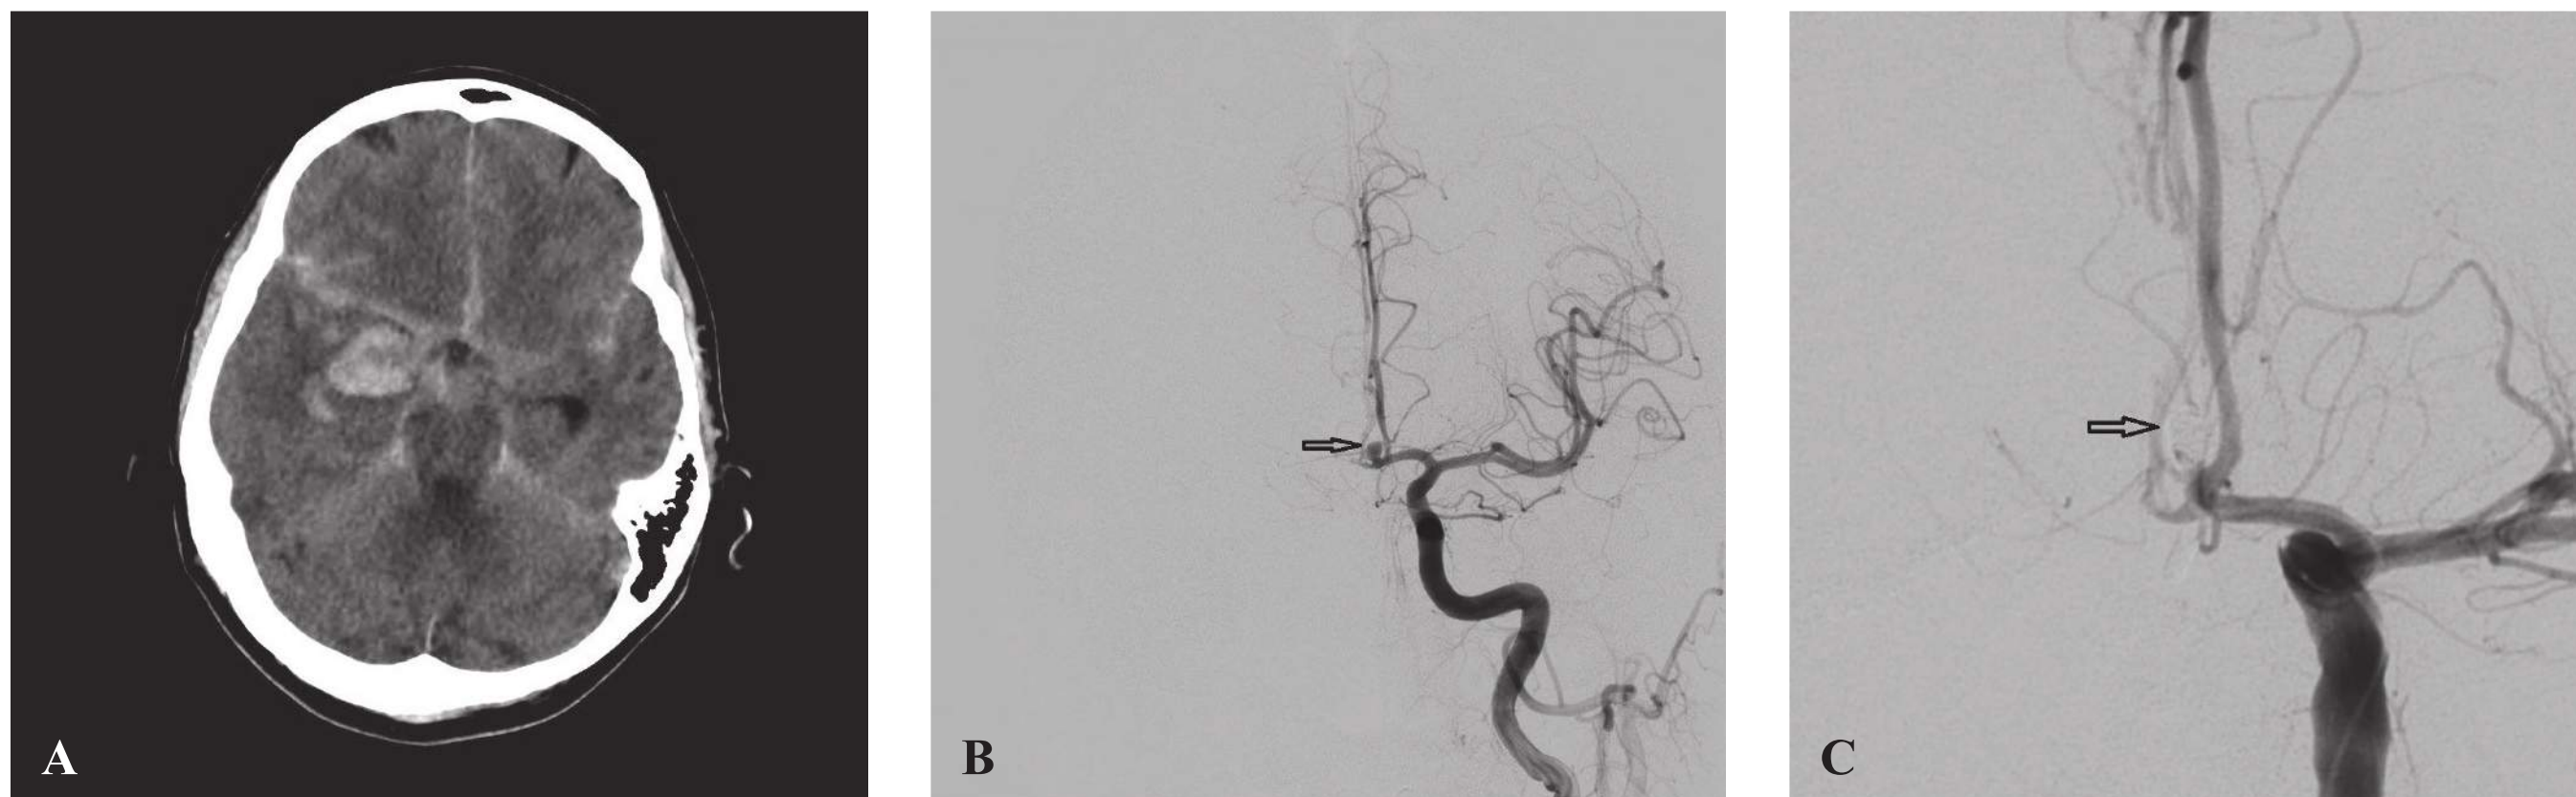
(A–C) CT scan demonstrates diffuse subarachnoid hemorrhage. CTA demonstrates an anterior communicating artery aneurysm pointing right and upward. This is confirmed on cerebral angiography. Post-aneurysm coil embolization angiogram is demonstrated. Note the lack of filling within the aneurysm.
